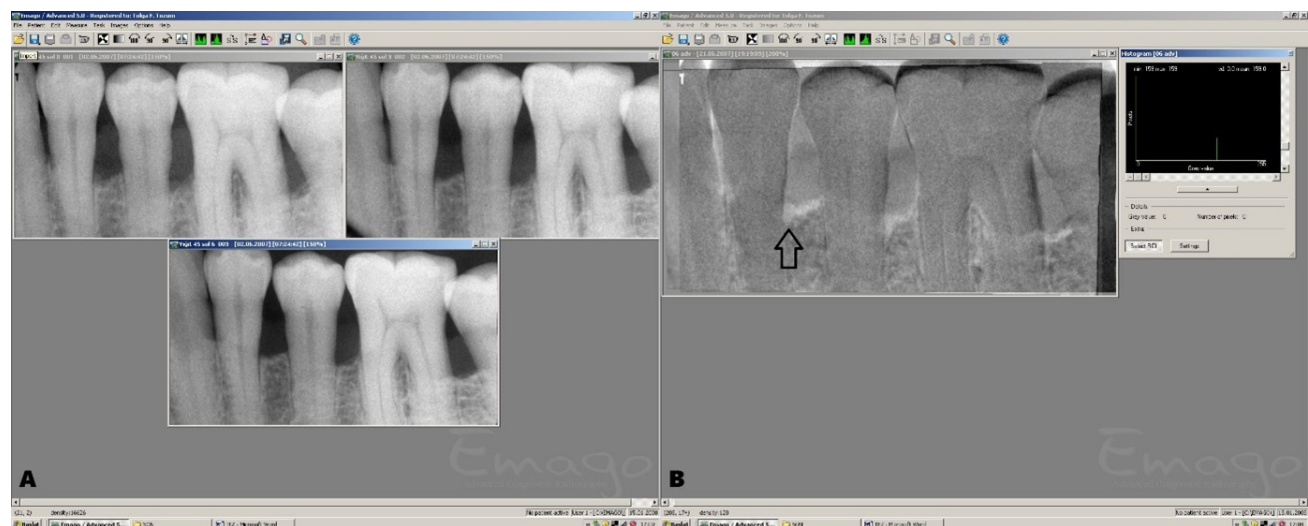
A. Periapical radiographs obtained at pretreatment, 3rd, 6th months. B. Digital Subtraction Radiography image; alveolar bone gain (arrow)
